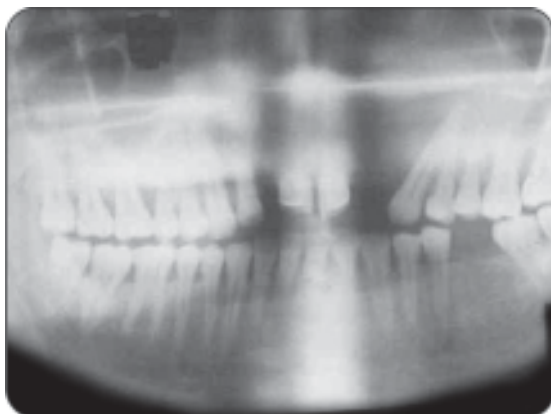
Radiograph of residual cyst causing displacement of the root of the neighboring teeth
